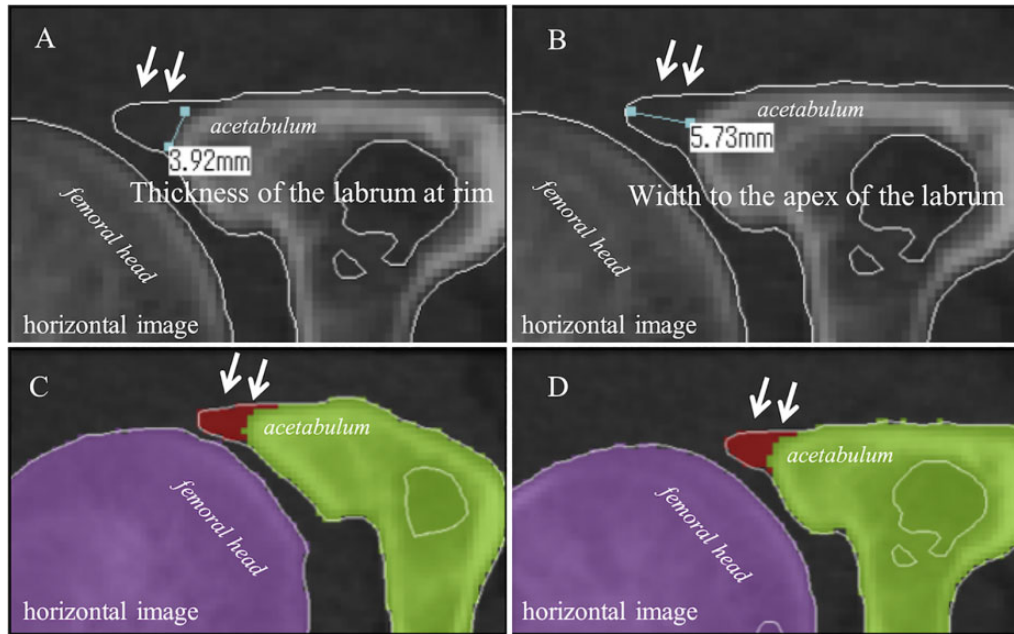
Reconstruction of the virtual acetabular labrum using Zed Hip (LEXI Co Ltd). Reconstruction of the acetabular labrum was based on its size measured on magnetic resonance imaging scans. The labral size was reflected in the Zed Hip reconstruction in each case. Specifically, the labrum was considered to be represented as a triangle on each horizontal slice, with the average thickness of the labrum forming the base and the distance to the apex forming the height (arrow in panels A and B, right-side hip joint). In this manner, the virtual labrum was added onto each slice using Zed Hip (arrow in panels C and D, right-side hip joint).
